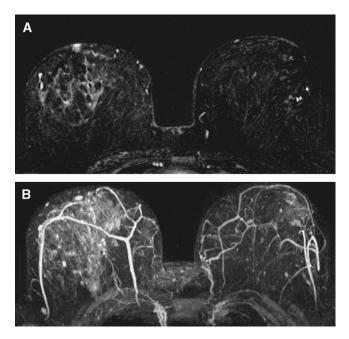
A 54-year-old woman with right invasive lobular cancer. (A) Axial T1 2-minute enhanced subtracted image, showing mild non-massenhancement in the right lateral and central breast with no mass. (B) Axial maximum intensity projection at 9 minutes, showing more diffuse gradual enhancement of the right breast. The asymmetric enhancement is helpful in making the diagnosis; the kinetic pattern is not helpful. The diagnosis was confirmed on ultrasound-guided breast biopsy (not shown).
